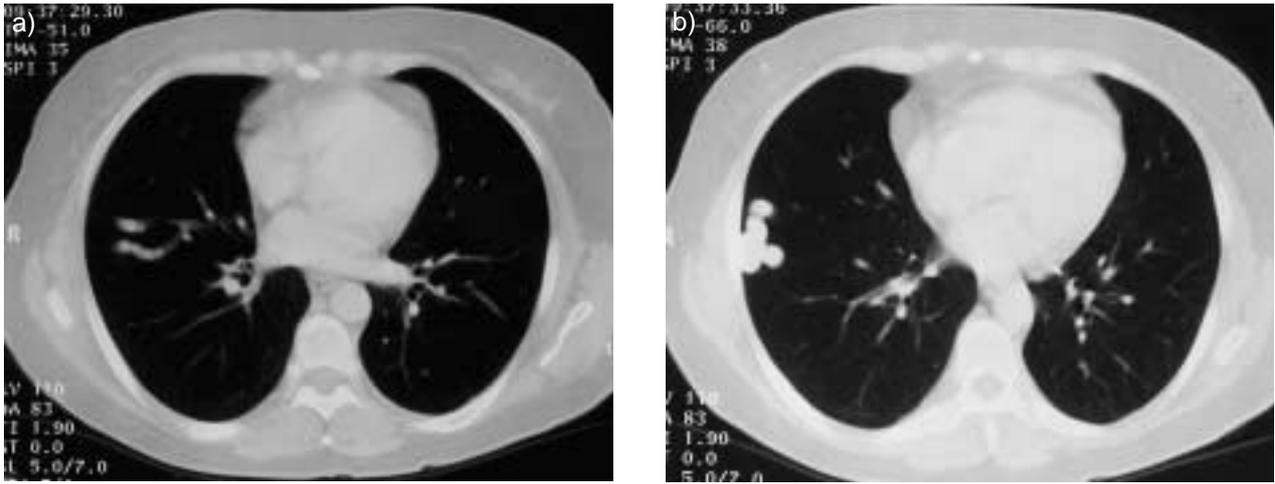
Thoracic computed tomography scan revealing proximal a) and distal b) views of the abnormality in the right lung.
